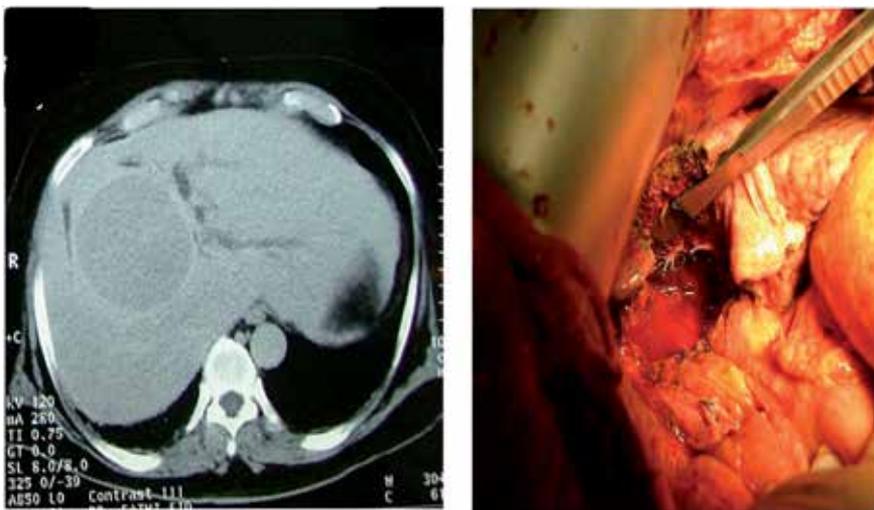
Central liver lesion as seen on CT scan and the same patient intra-operatively after resection
